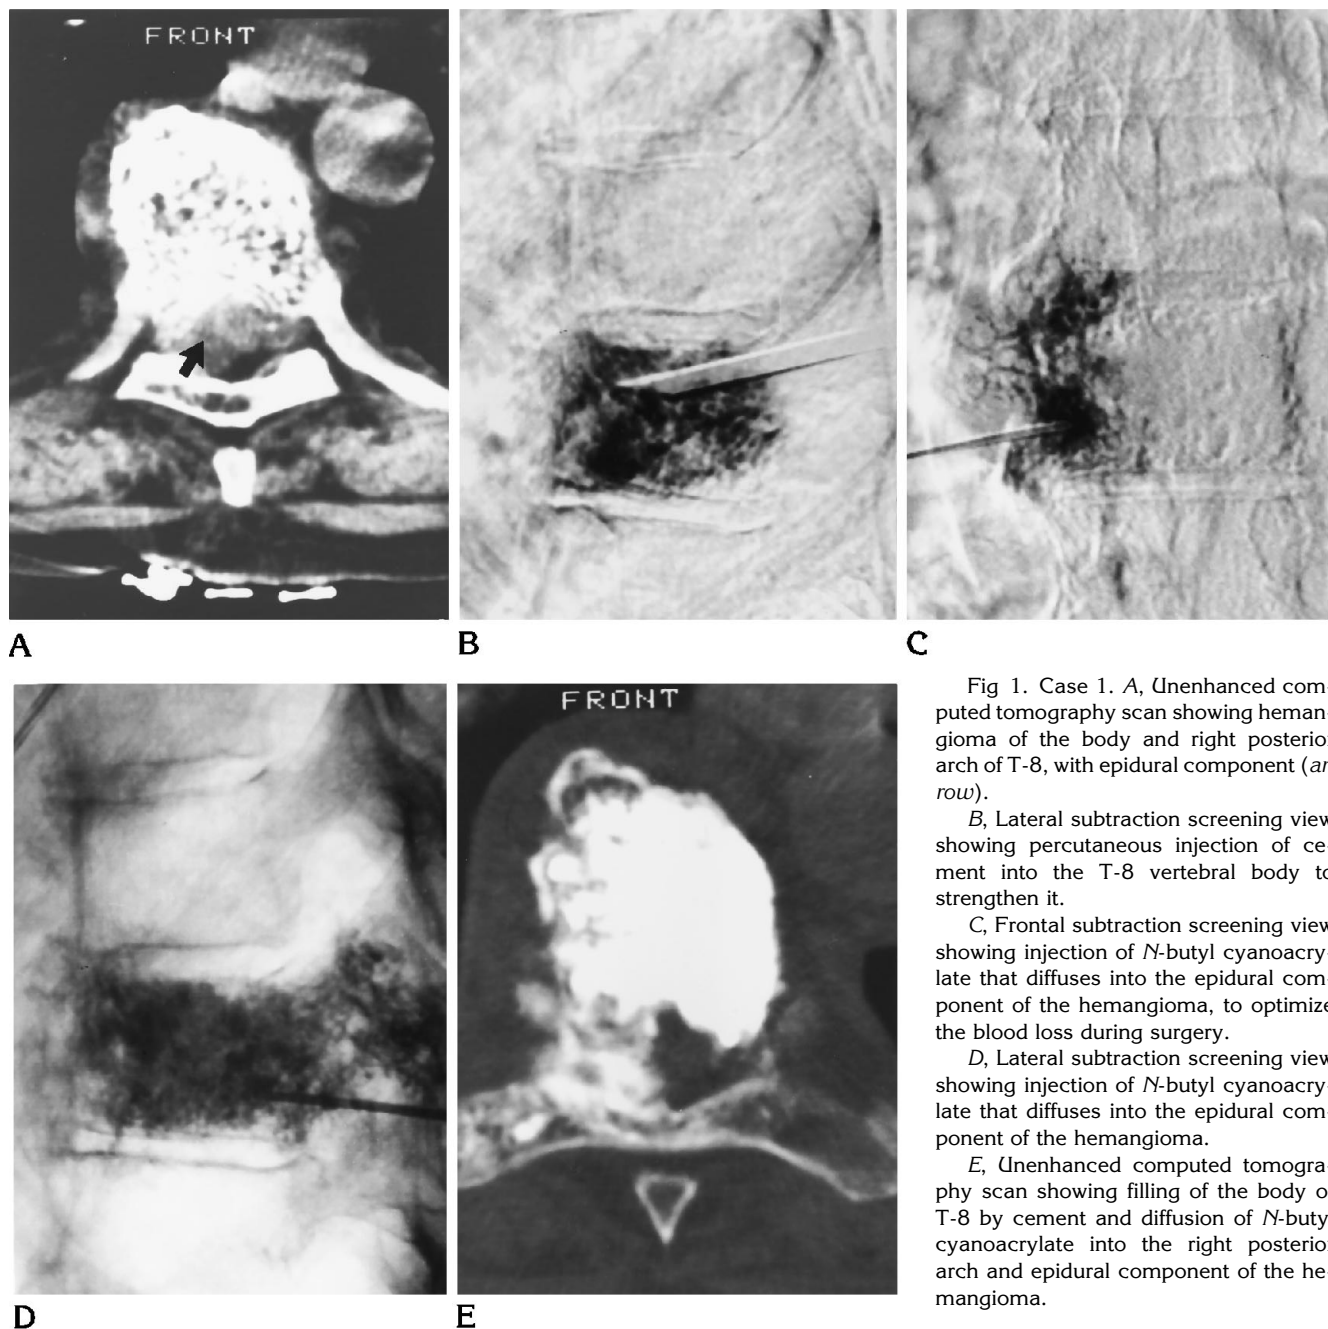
Case 1. A, Unenhanced computed tomography scan showing hemangioma of the body and right posterior arch of T-8, with epidural component (arrow).
